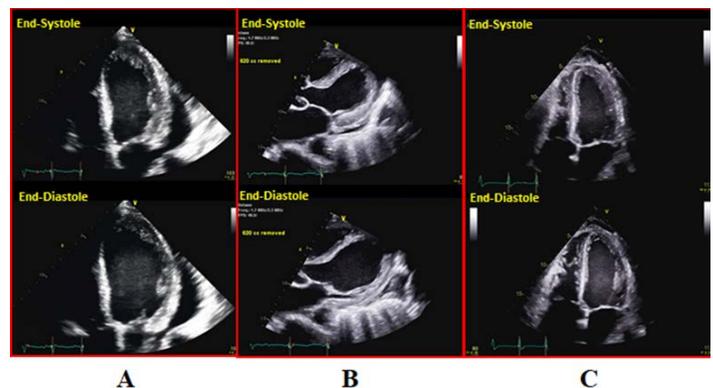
End-systolic and end-diastolic four chamber view in echocardiogram. Panel A shows the cardiac profile in the presence of pericardial effusion. Panel B shows cardiac function immediately after post-pericardiocentesis. Panel C shows reduced cardiac function 24 hours after the pericardiocentesis.
